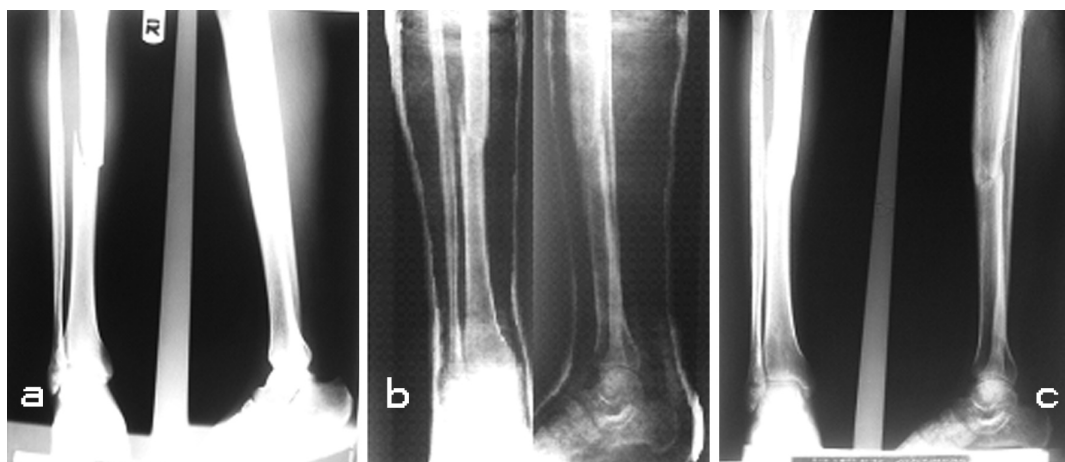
Case2: 24 years old female, (a) initial radiography, type A1.1 (b) after casting, (c) after 6 months, 6° varus and 4° anterior bowing.
